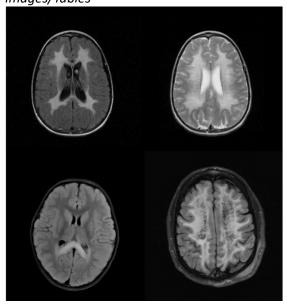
(A) Axial FLAIR images in an 8 yearold with previously diagnosed metachromatic leukodystrophy demonstrate symmetric periventricular white matter hyperintensity with sparing of the subcortical U-fibers . (B) T2 images in the same patient show a "tigrioid stripe" appearance of the periventricular white matter. (C) Axial FLAIR images in a 4 year-old with x-linked adrenoleukodystrophy demonstrate bilateral peritrigonal hyperintensities with involvement of the splenium of the corpus collosum. (D) Axial FLAIR images in a 6 year-old demonstrate periventricular and subcortical hyperintensities with "tigroid stripes" consistent with a known history of vanishing white matter disease.
